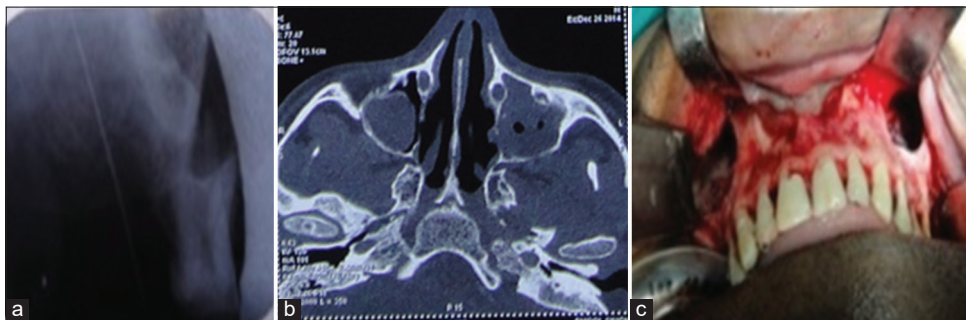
(a) Intraoral periapical with gutta-percha point, (b) Computed tomography scan showing obliteration of maxillary sinus, (c) Intraoperative image of sinus after excavation of keratocystic odontogenic tumor (Case 5)
